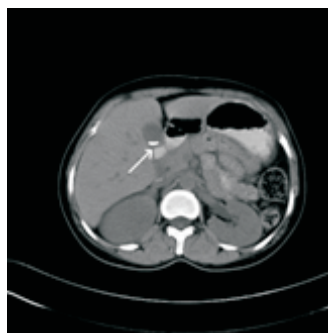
Axial plain CT scan image showing multiple hyper dense calculi in the gall bladder.
